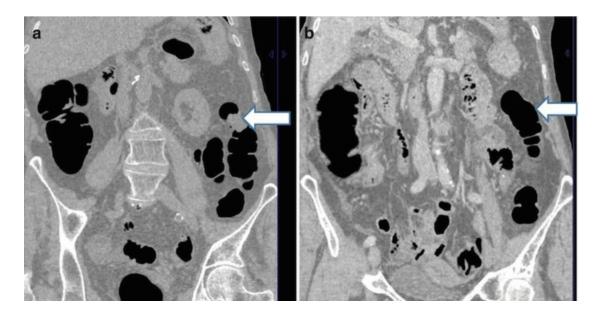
(a, b) Patient admitted because of large bowel symptoms. CT colonography shows focal masslike structure in the descending colon in prone position (a, *arrow*), while the same colon segment appears normal on images obtained shortly thereafter in the supine position (b, *arrow*). The finding represents a focal contraction of the colon, sometimes seen on abdominal CT, and represents a potential source of false-positive colonic finding on abdominal CT
